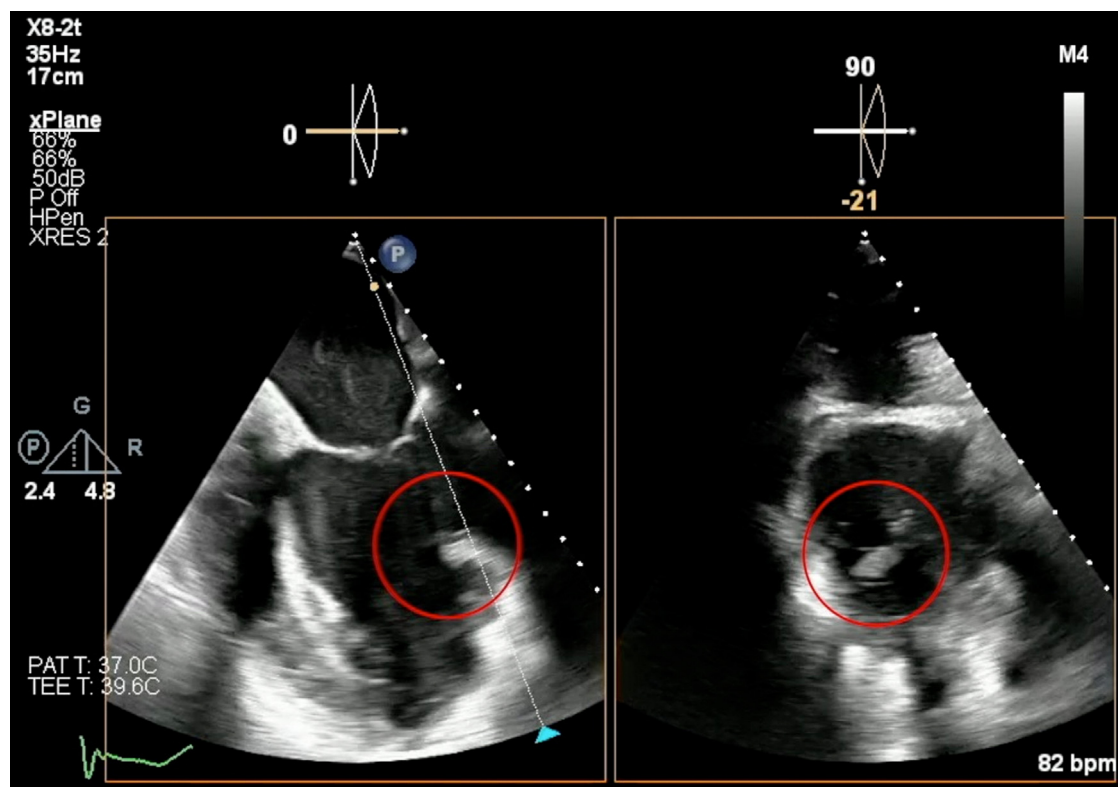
Transesophageal echocardiography prior to separation from cardiopulmonary bypass showing an echogenicity (circled in red) in relation to the lateral wall of the left ventricle. TEE, transesophageal echocardiography.
